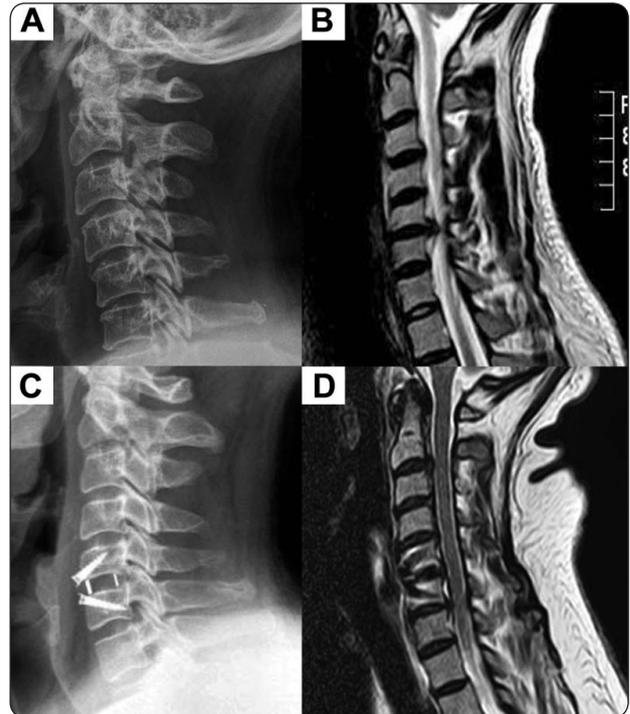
A: Pre-operative X-ray, B: Sagittal T2 MRI cervical spine showing C5-6 disc prolapse. C: Two months post-operative X-ray, D: Post-operative Sagittal T2 MRI.
